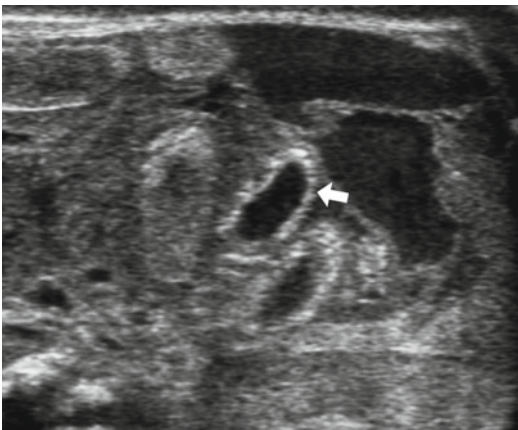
Ultrasound exam in newborn with NEC with parietal pneumatosis in distended loops shows the “circle” sign (*white arrow*)
